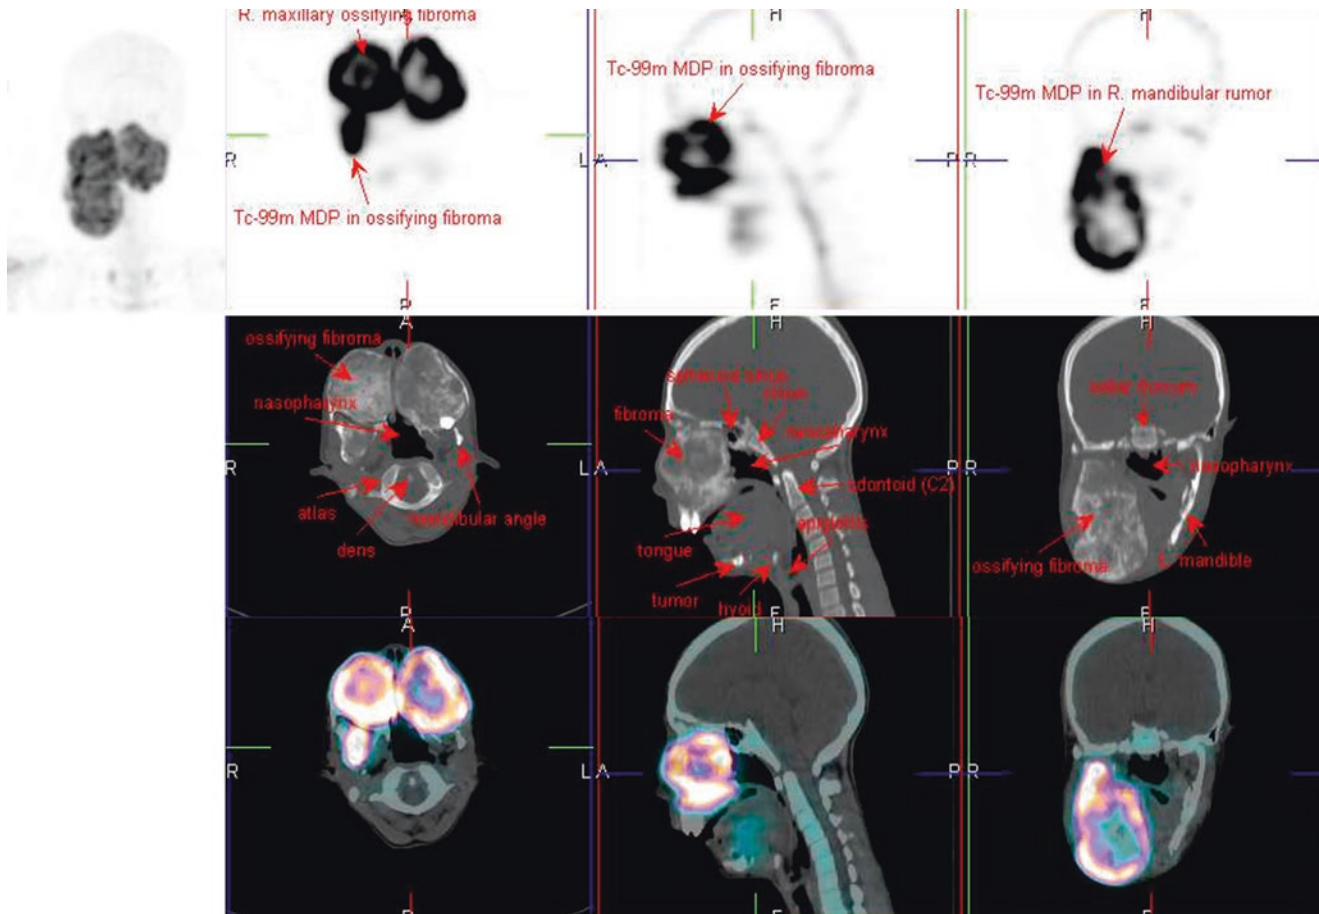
^{99m}Tc -MDP SPECT/CT
